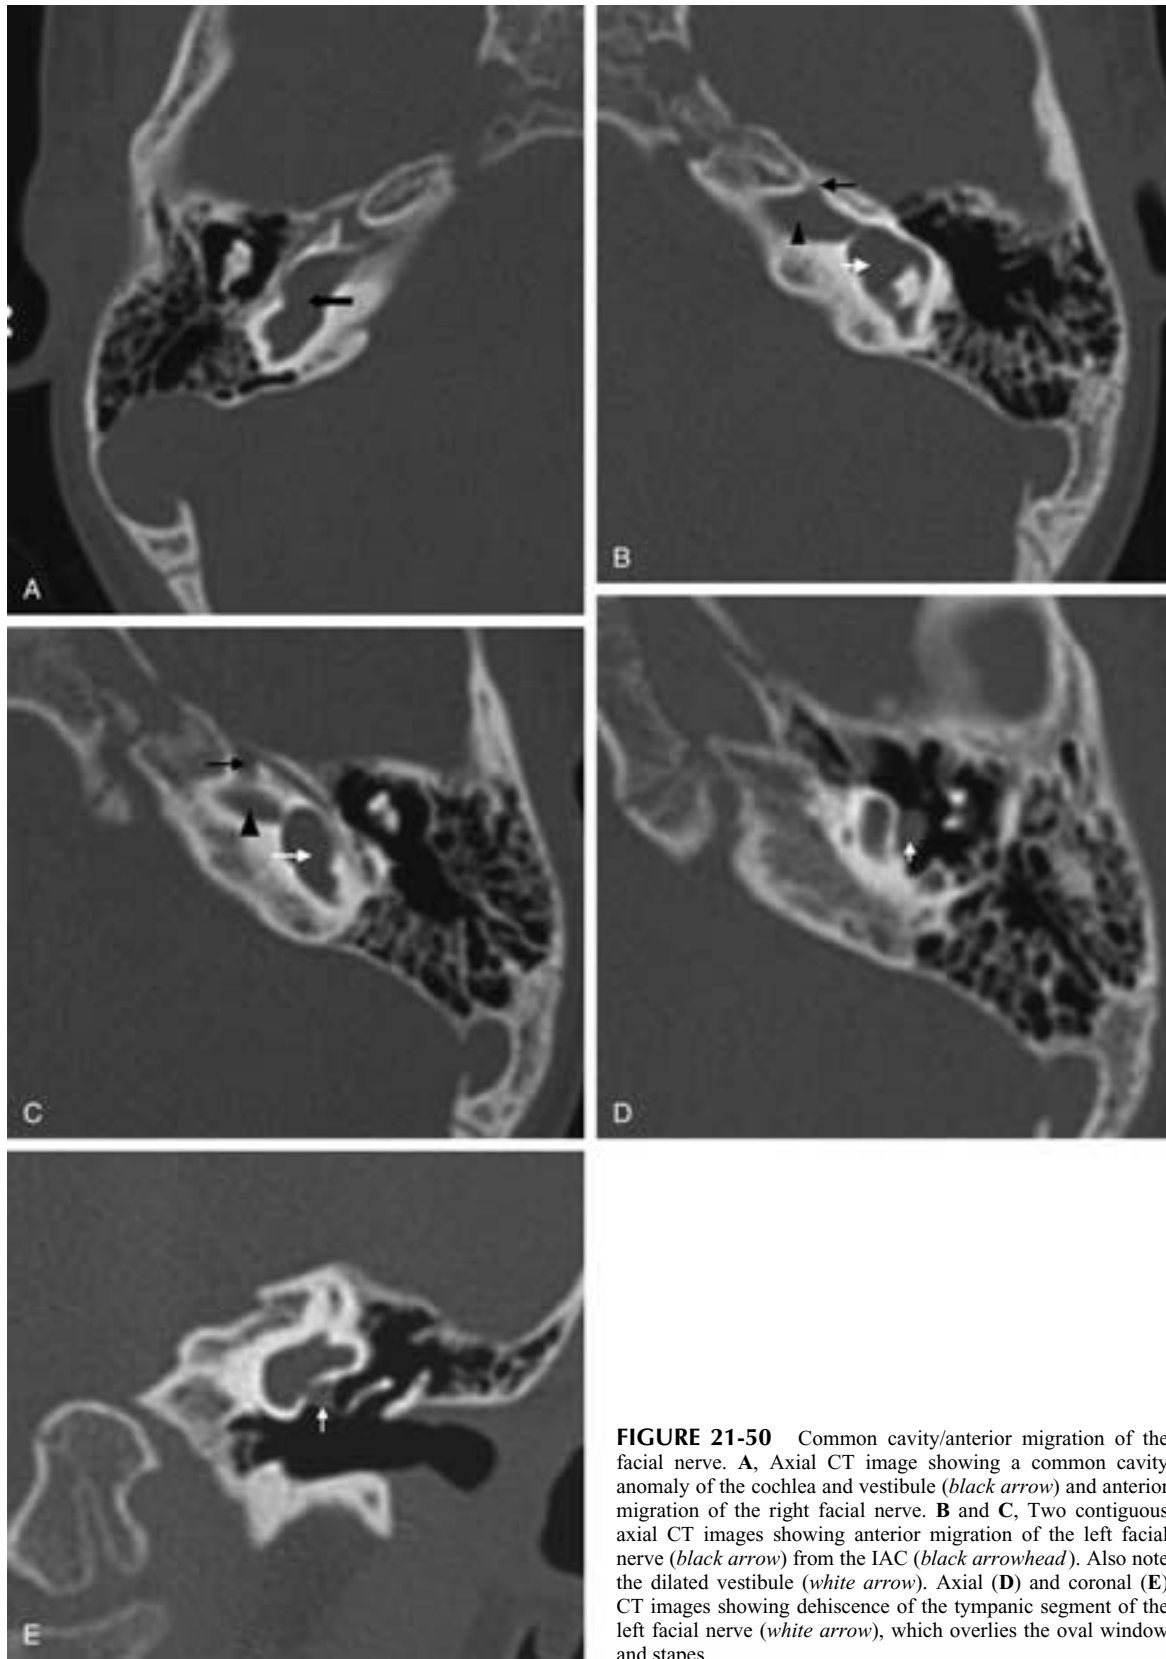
Common cavity/anterior migration of the facial nerve. A, Axial CT image showing a common cavity anomaly of the cochlea and vestibule (*black arrow*) and anterior migration of the right facial nerve. B and C, Two contiguous axial CT images showing anterior migration of the left facial nerve (*black arrow*) from the IAC (*black arrowhead*). Also note the dilated vestibule (*white arrow*). Axial (D) and coronal (E) CT images showing dehiscence of the tympanic segment of the left facial nerve (*white arrow*), which overlies the oval window and stapes.
